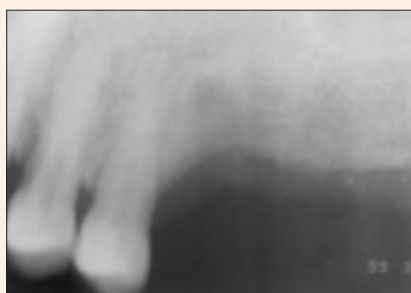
A periapical radiograph taken during the 2-week follow-up visit.
